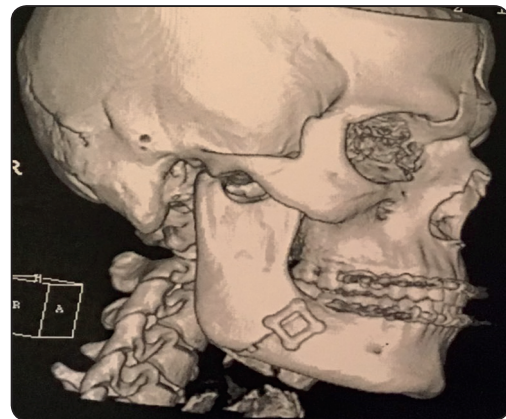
3d CT scan showing fixation of angle fracture with 4 holes 3d-strut plate one week postoperatively without any hardware failure.
